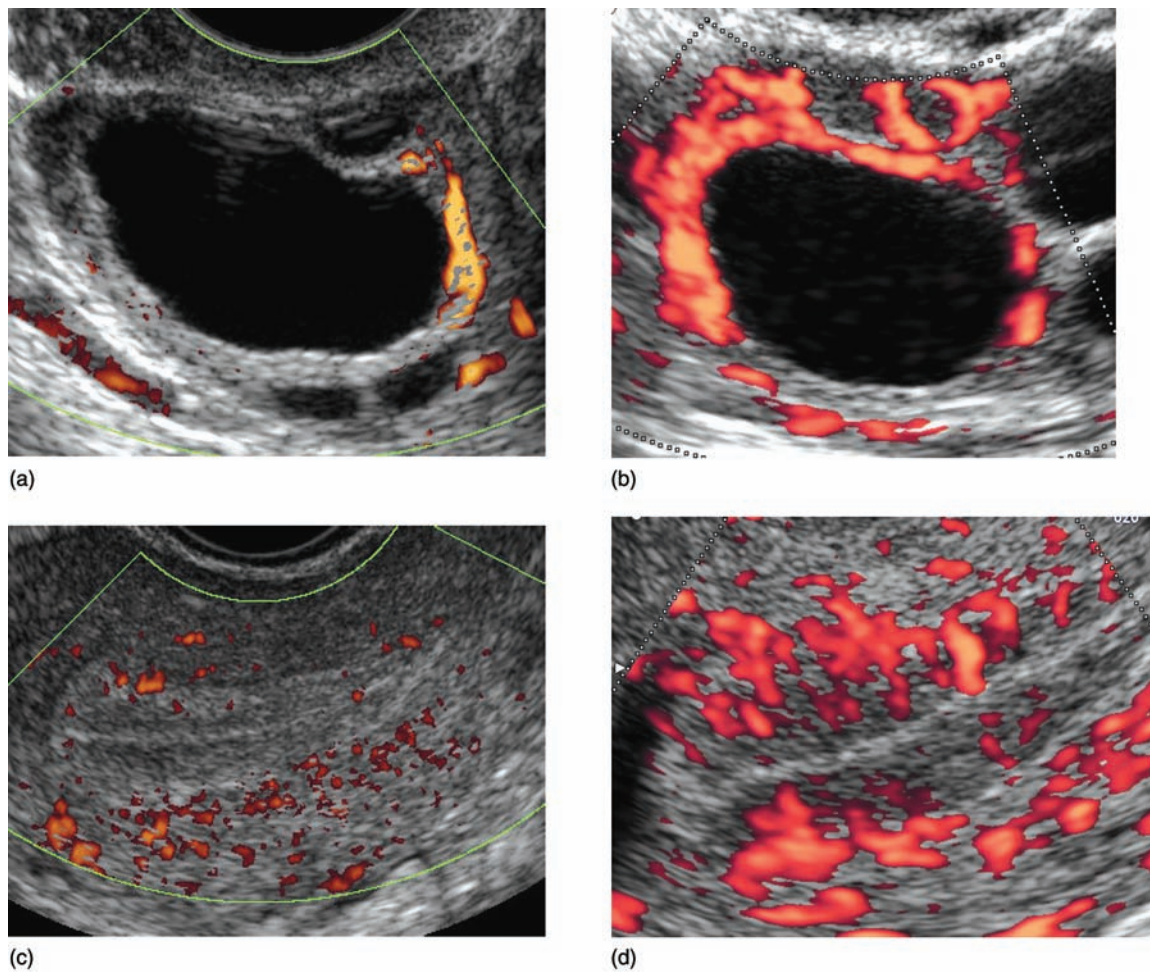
Power Doppler mapping of the follicular and endometrial blood flow. (a) Grade I, color mapping encircles less than 25% of the follicular circumference. (b) Grade IV, Doppler signal occupies 76–100% of follicular perimeter. (c) Type I endometrial mapping or peripheral flow, with color signal is visible at myometrium and only reaches outer hyperechogenic endometrial layer. (d) Type III endometrial mapping or central flow, as the color mapping is distributed through the whole endometrial thickness.
